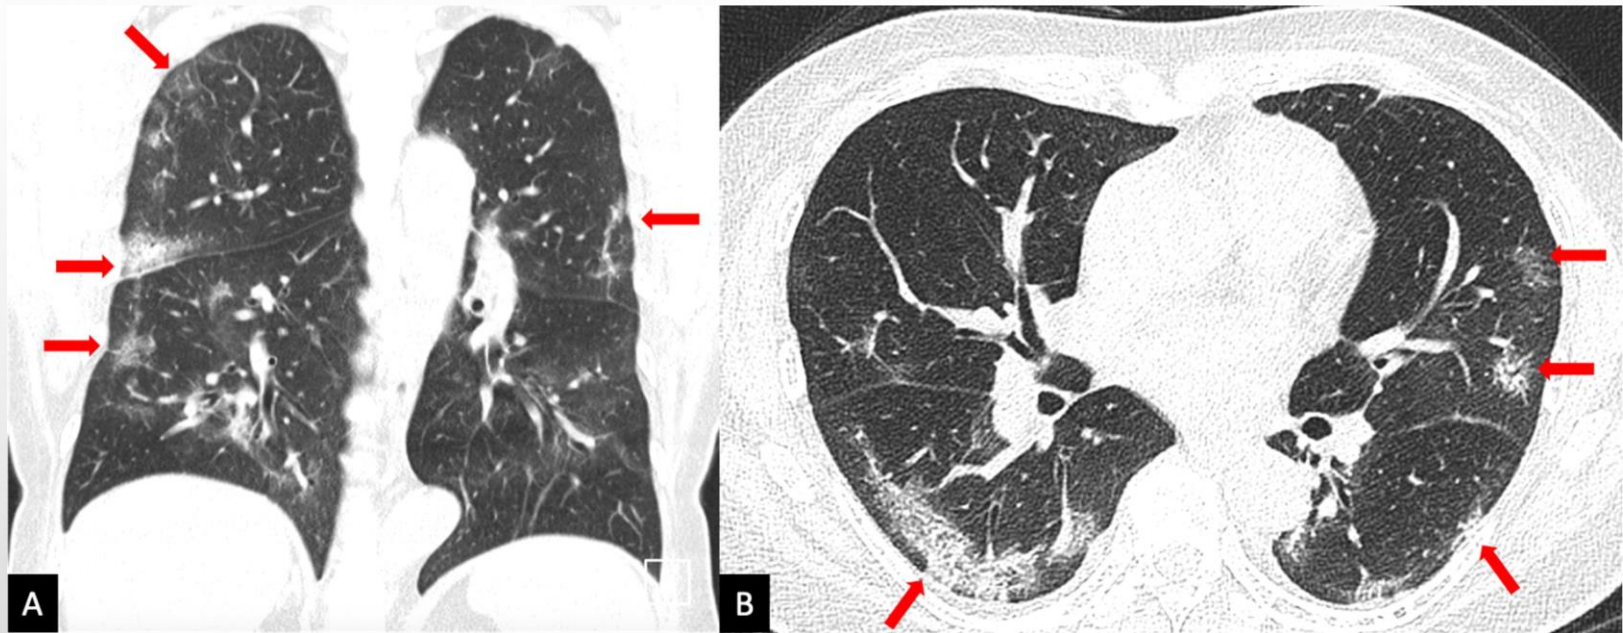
A 65-year-old female patient who had travelled to Wuhan, China, subsequently developing fever and cough 5 days after arrival. She subsequently returned to Shenzhen, China, and had this chest CT 7 days after symptom onset. Coronal and axial CT images (A & B) showing a mixture of ground glass and consolidation in the periphery of the lungs (red arrows), with absence of pleural effusions, which was the typical appearance of patients with confirmed COVID-19 infection.
